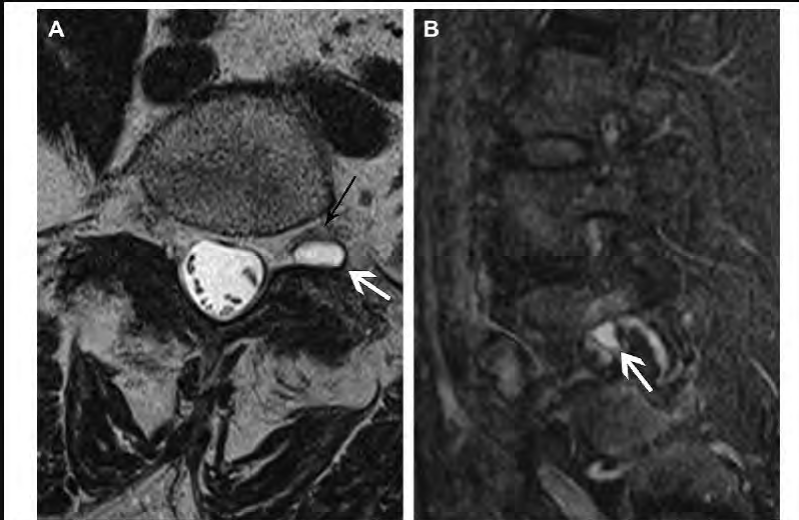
Synovial cyst in the neural foramen. A 50-year-old woman presents with LBP radiating down the left leg to the foot. Axial FSE T2-weighted sequence (A) shows a cystic structure in the left L5 neural foramen (white arrow) compressing the exiting nerve root (black arrow). Sagittal STIR sequence (B) more clearly demonstrates that the cyst (white arrow) arises from a degenerated facet joint with associated synovial effusion, pedicle and periarticular soft-tissue edema.
